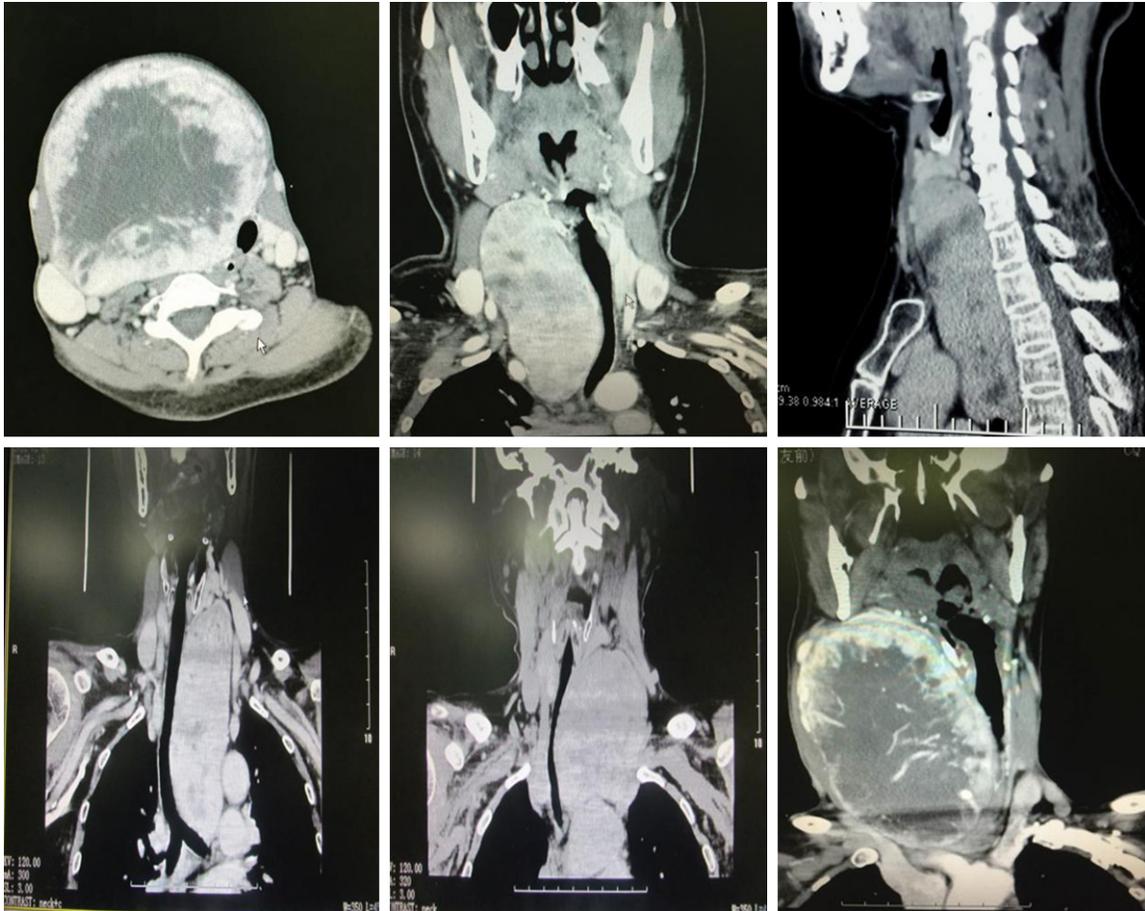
CT of the neck: thyroid was enlarged significantly, the trachea was deformed and displaced due to compression, and become stenotic.
